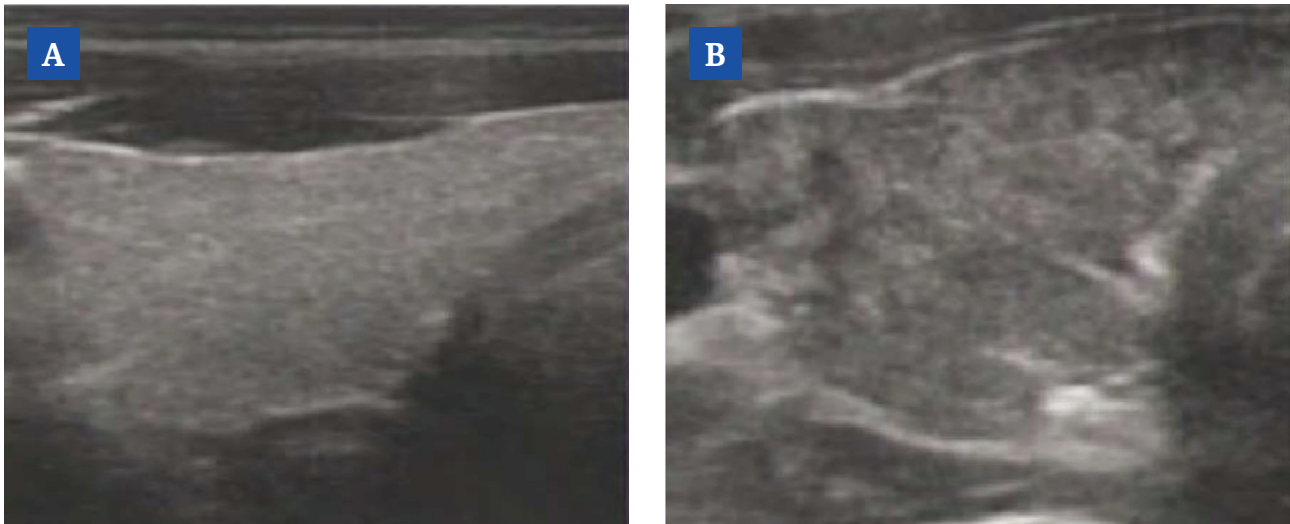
Echocardiogram of the thyroid: A – normal variant; B – structural changes according to the hypoechoic and heterogeneous variant with single hypoechoic foci (patient V., 39 years old, suffering from AIT for 8 years).
